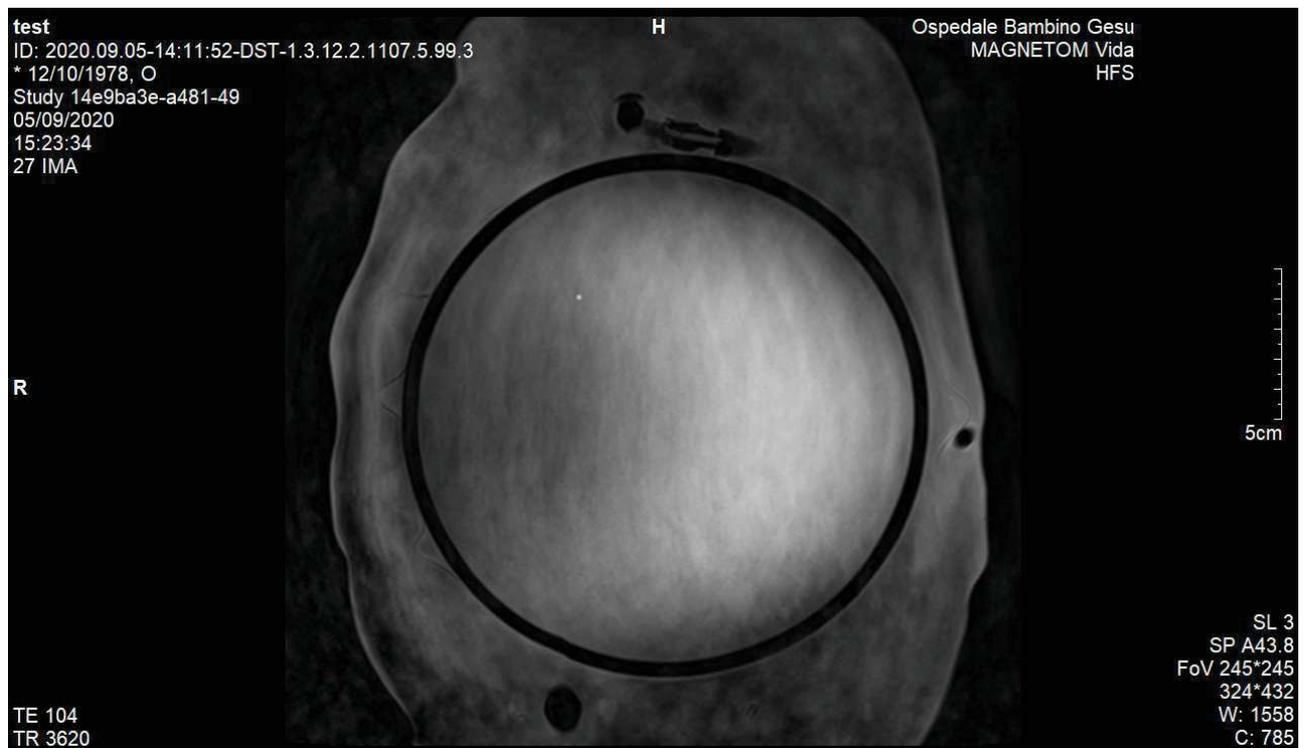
MRI scanned image
